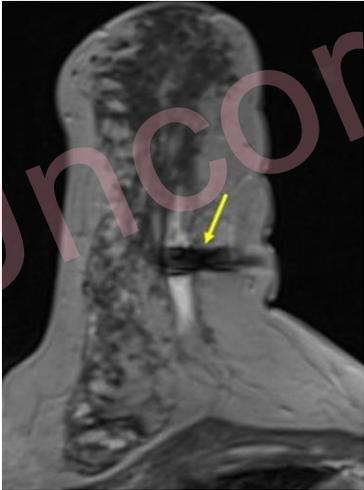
On precontrast T1W MRI, there was a 4 cm hypointense asymmetric tissue with irregular borders in the upper inner quadrant of the right breast. On the postcontrast T1W image nonmass enhancement was seen which became more evident in 3 month follow-up.
